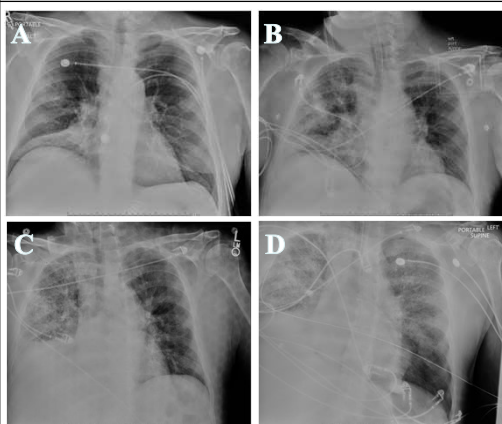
Daily chest x-ray comparison and progression of right lower lobe localized infiltrate (A) to diffuse bilateral infiltrates (D)
